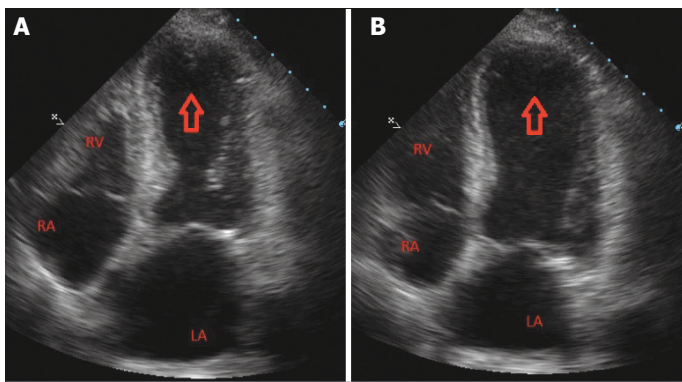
Transthoracic echocardiography demonstrating apical hypokinesia with an ejection fraction estimated at 36% in apical 4-chamber view. (A) Left ventricle systole. (B) Left ventricle diastole, red arrow; apical hypokinesia. (LA: left atrium; RA: Right atrium; RV: Right ventricle).
